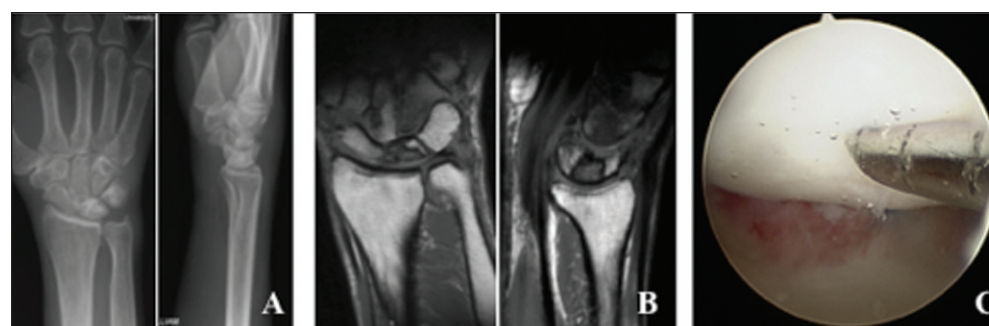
Arthroscopic staging in Kienbock's disease. Intraoperative standard radiographs showing sclerosis and deformity of the lunate in radiographic Lichtman IIIb stage (A). Intraoperative reduced lunate signal on T1-weighted magnetic resonance imaging indicative of an avascular lunate (B). Intraoperative arthroscopic probe penetrates lunate cartilage and subchondral bone for several millimeters. This demonstrates the loss of osteochondral integrity, confirming that the disease stage is not amenable to revascularization procedures (C).
